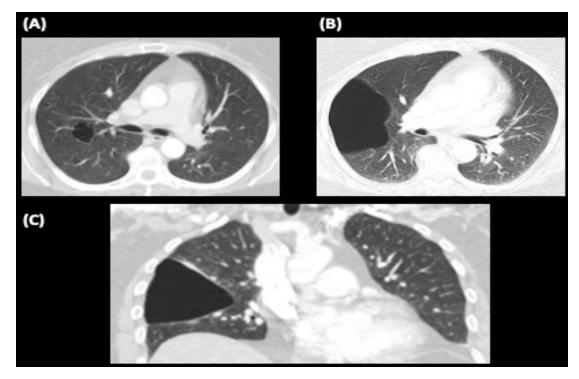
Case threw. (A) Chest CT image taken 13 years prior to presentation showing a small right middle lobe bulla. (B) Transverse and (C) sagittal chest CT images taken 4 years prior to presentation showing significant interval growth of the bullae.
